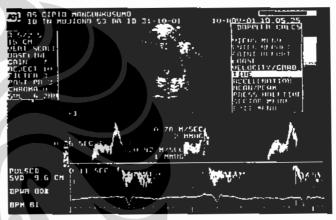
Diastolic Dysfunction Demonstrated Using Echo-doppler.
